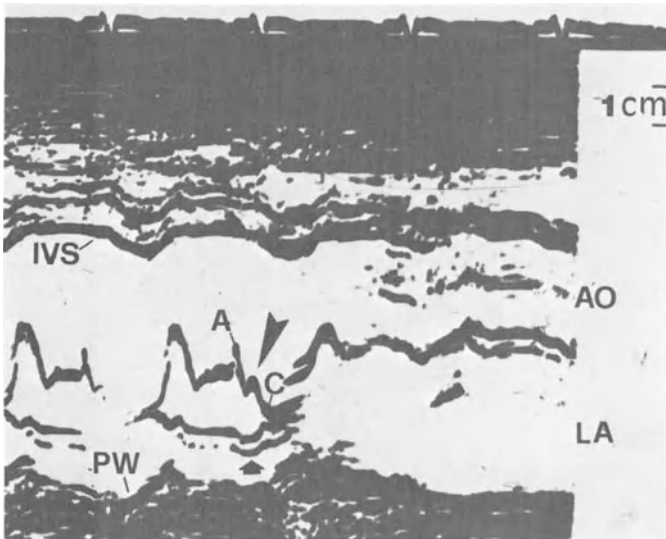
Abnormal echocardiogram showing a thin (PW) scarred and dyskinetic posterior wall in a patient with myocardial infarction of posterior wall. Arrow indicated a markedly increased atrial component; anterior movement of anterior mitral leaflet at the end-diastole, which reflects changes in left ventricular end-diastolic pressure.
